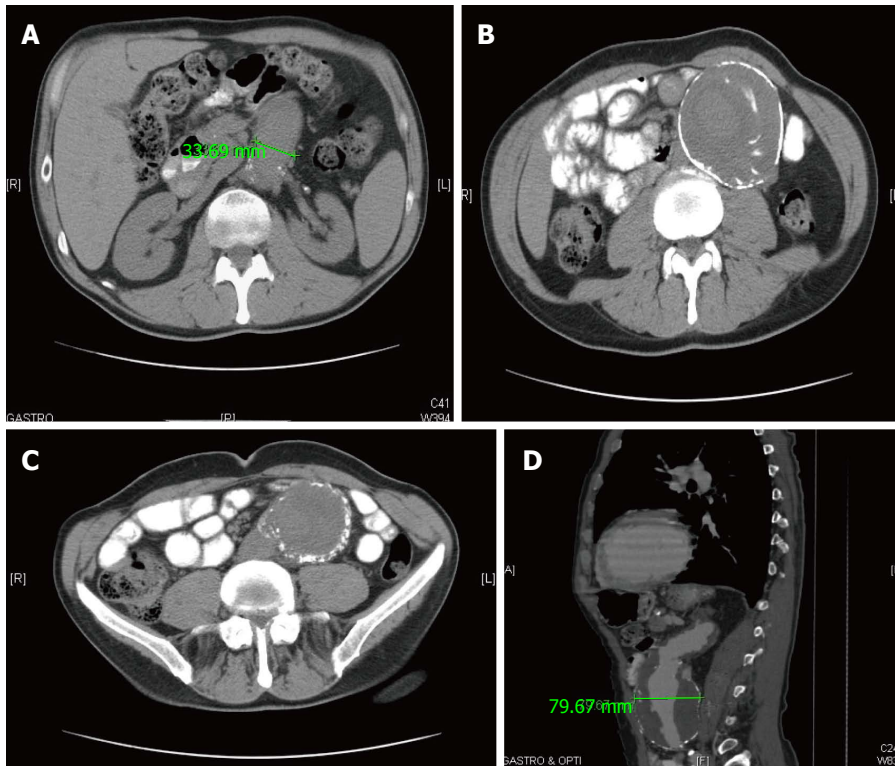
Computed tomography scan. A: Showing aortic abdominal aneurysm at the level of renal arteries; B: Showing massive unruptured abdominal aortic aneurysm along with loops of small intestine; C: Showing continuation of abdominal aortic aneurysm along with plaques of calcification surrounding it; D: Showing longitudinal section of contrast filled abdominal aortic aneurysm with bilateral mural thrombus.
